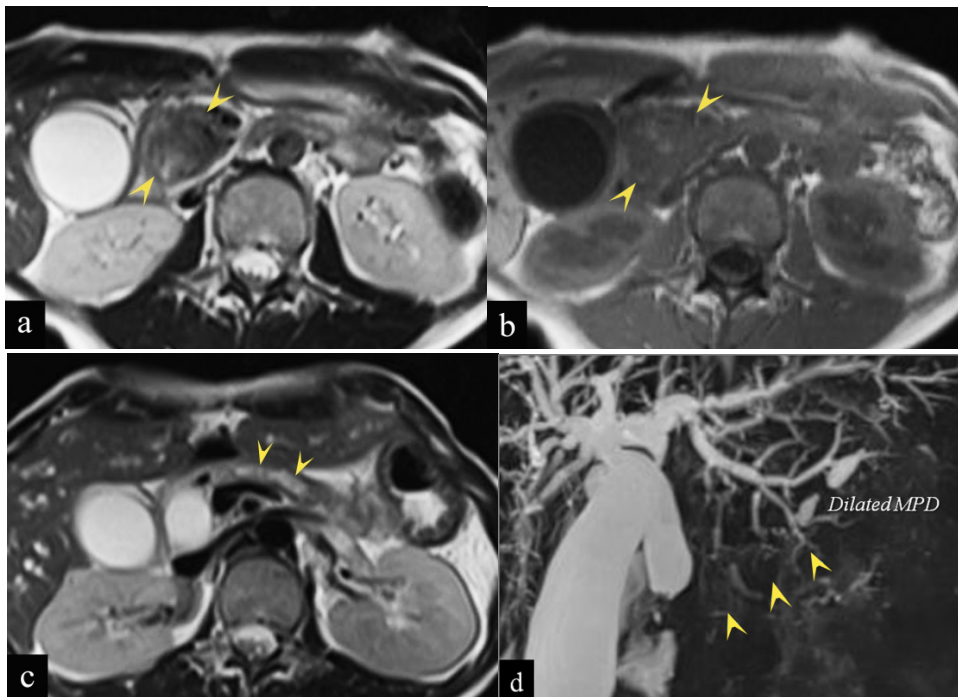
The pancreatic head mass is seen as inhomogeneously low signal intensity (arrowheads) on T2-weighted (a.) and T1-weighted (b.) images. The intraductal lesion of the pancreatic body showed high signal intensity (arrowheads) on T2-weighted image (c.). MR cholangiopancreatography (d.) shows obstruction of the main pancreatic duct in the pancreatic head to body (arrowheads), with dilatation of the upstream duct.
